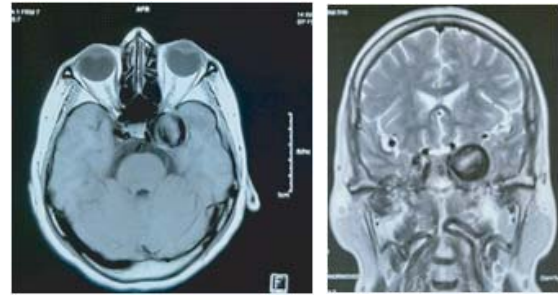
MRI of brain: Well circumscribed lesion in left parasellar region
